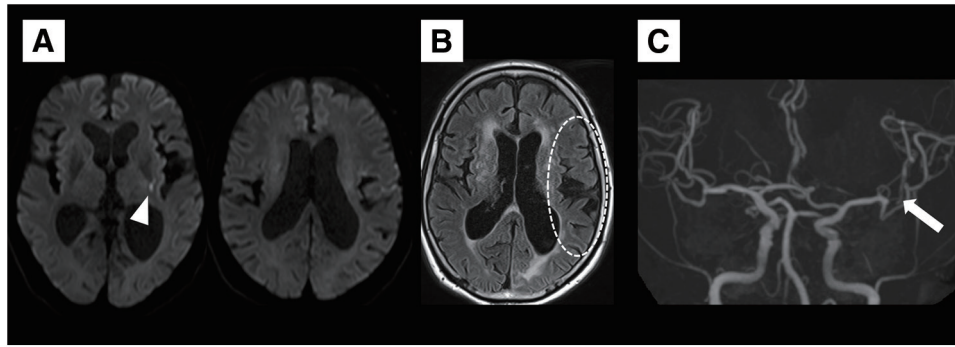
MRI the day after endovascular therapy. (A) Diffusion-weighted MRI showed a small high-signal intensity area in the left putamen (white triangle). (B) FLAIR imaging revealed the resolution of the HVS in the left MCA territory (white dotted circle). (C) MRA showed that the left MCA M2 segment maintained recanalization, although its origin was severely stenosed (white arrow). HVS, hyperintense vessel sign; MCA, middle cerebral artery
